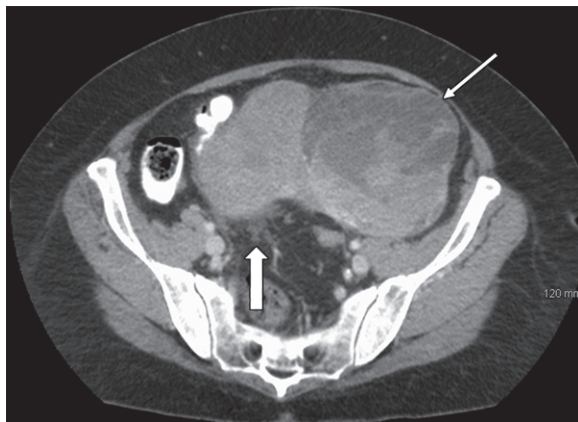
Axial contrast-enhanced image from abdominopelvic CT performed at an outside hospital. The interpreting radiologist identified a mass (thin arrow) in the left pelvis but incorrectly attributed it to an exophytic fibroid. The imaging appearance is not characteristic of a fibroid, and the interpreting radiologist missed small implants in the right dependent pelvis (thick arrow). The patient was eventually referred to gynecology-oncology at an academic hospital; the findings proved to represent ovarian cancer.
